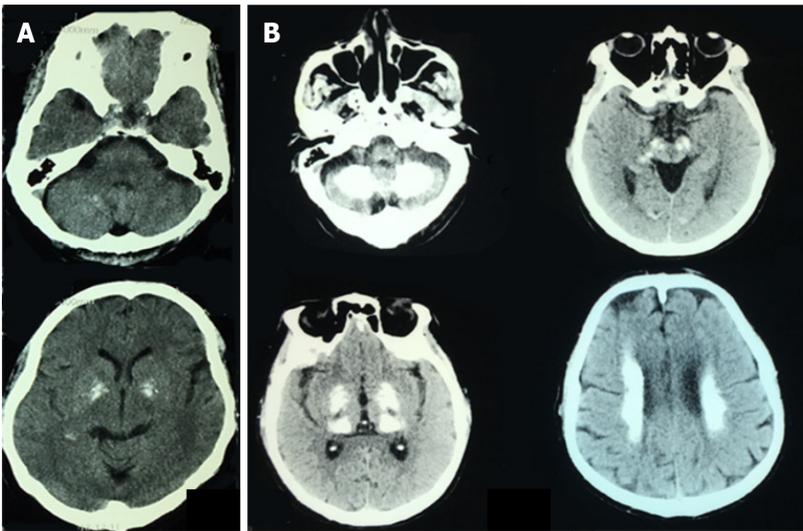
Computed tomography. A: Basal ganglia and cerebellum calcification of patient's sister; B: Patient's symmetric calcifications of bilateral basal ganglia, cerebellum, thalamus, and periventricular area.
